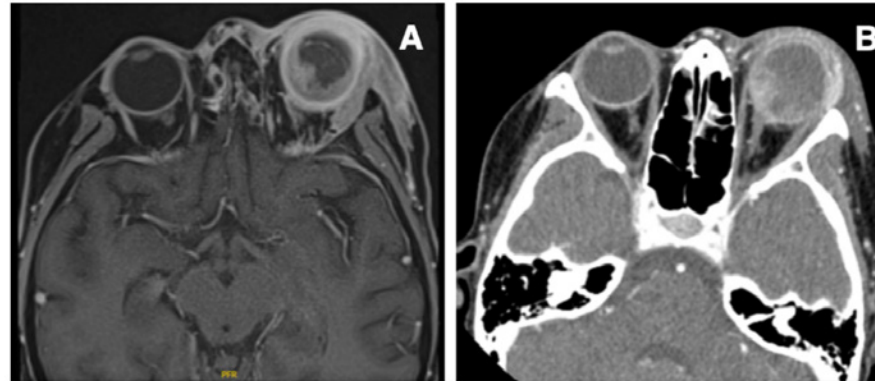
A) Magnetic resonance imaging and B) CT scan showing hyperintensity/hyper-density in the posterior left globe and thickening of periorbital soft tissue in the left orbit
